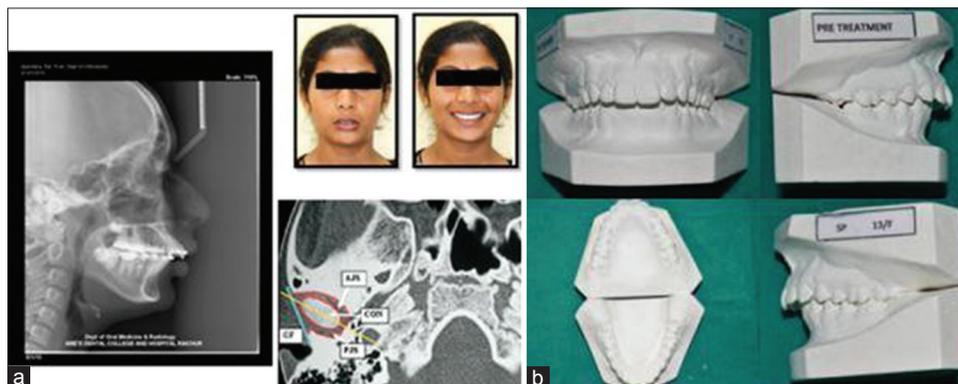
(a) Pretreatment lateral cephalogram, study models and extraoral photographs, and computed tomography image. (b) Pretreatment models
